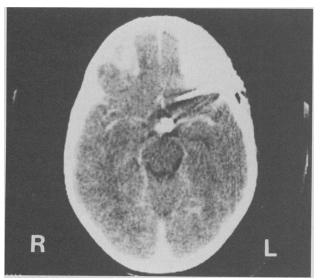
One year after intracavitary instillation of 5 mL of ³²P with a total activity of 0.5 mCi, the cyst with residual suprasellar calcification is seen completely collapsed on computed tomography scan of the head
